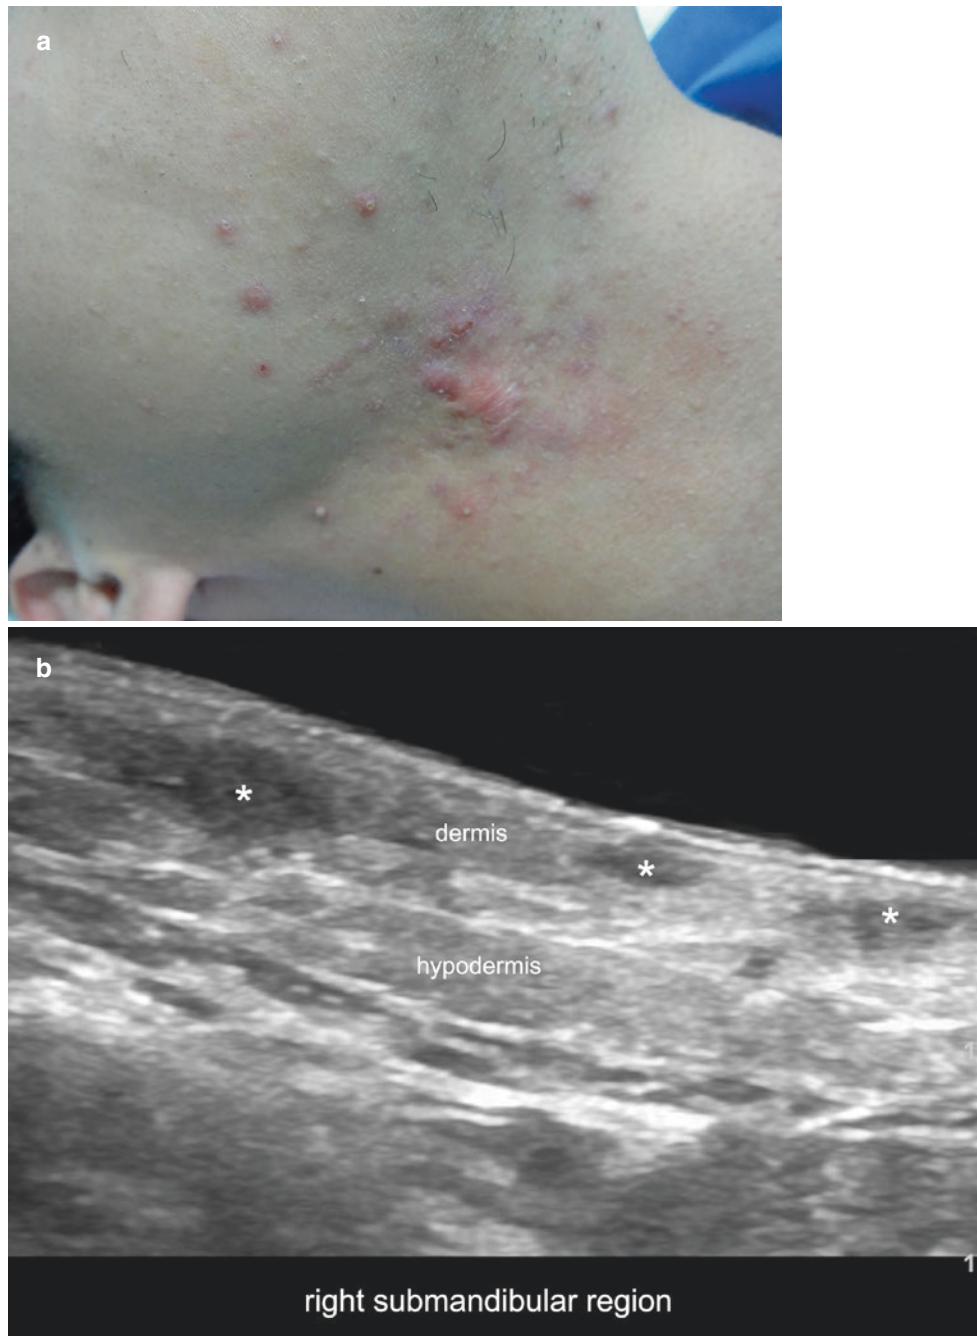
Acne. (a) Clinical image. (b) Greyscale (longitudinal view; right mandibular region) shows three oval-shaped, hypoechoic structures (*asterisks*) suggestive of pseudocysts; the larger pseudocyst is located in the dermis and upper hypodermis; the two smaller pseudocysts present a dermal location. (c) Ultrasound (greyscale, longitudinal view; right mandibular region) shows a hypoechoic, band-like dermal
